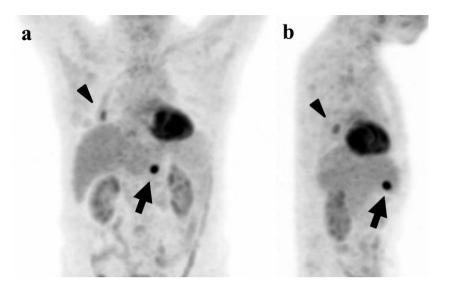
FDG uptake was detected in metastatic lesions in the gastric lymph node (arrow) and lung (arrow head) in the anteroposterior (a) and the lateral (b) views of FDG/PET-CT images.
